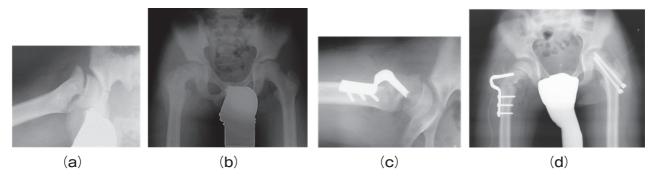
Lateral (a) and anteroposterior (b) radiographs before surgery. Lateral (c) and anteroposterior (d) radiographs after surgery. The PTA improved from 55° to 25° after surgery.
